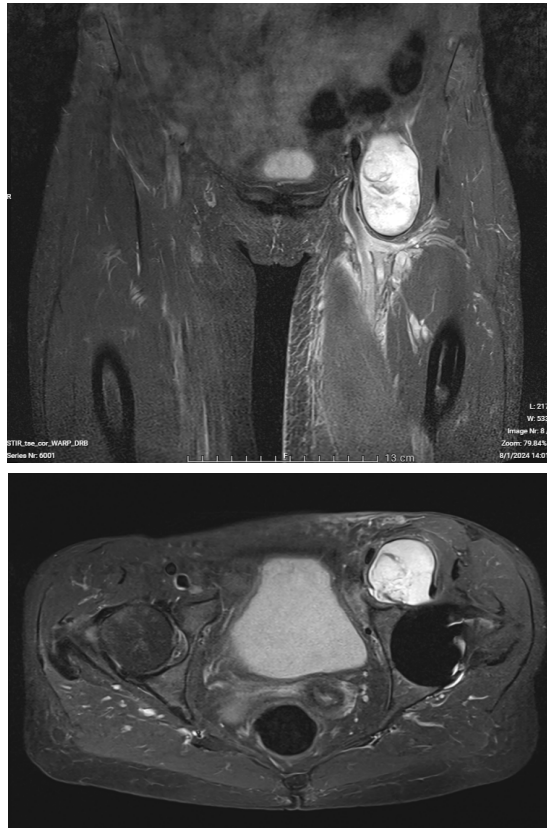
Coronal (a) and axial (b) MRI images of the fluid-filled mass, compressing the femoral artery and vein.
